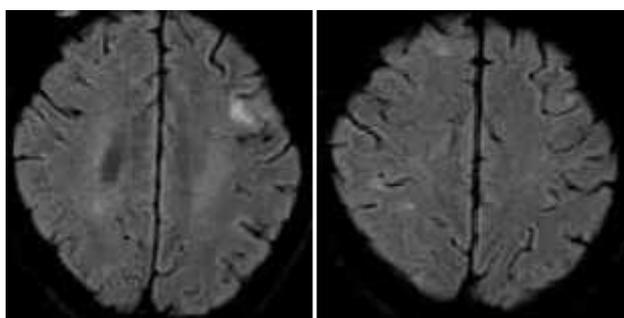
(a,b) MRI Brain- Axial - FLAIR
